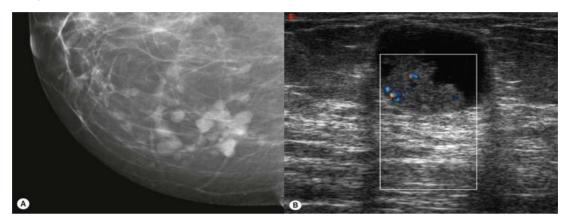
Shows multiple small papilloma. (A) Papillomas are frequently well defined on mammography, although part of the mass may have an irregular or ill-defined contour. (B) On ultrasound, the presence of a filling defect within a cystic structure suggests the diagnosis. Colour Doppler can be useful for distinguishing debris within a cyst from a soft-tissue mass (.MacGrogan G,et al,2003).
